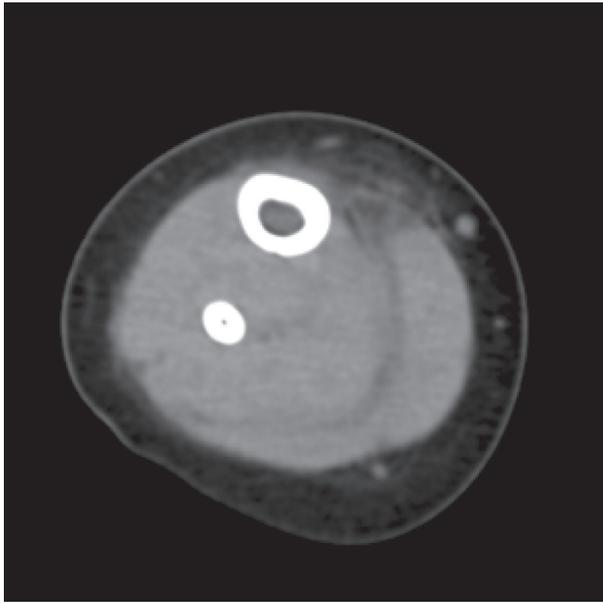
Axial plain CT image of the right lower leg. No obvious gas was seen.
